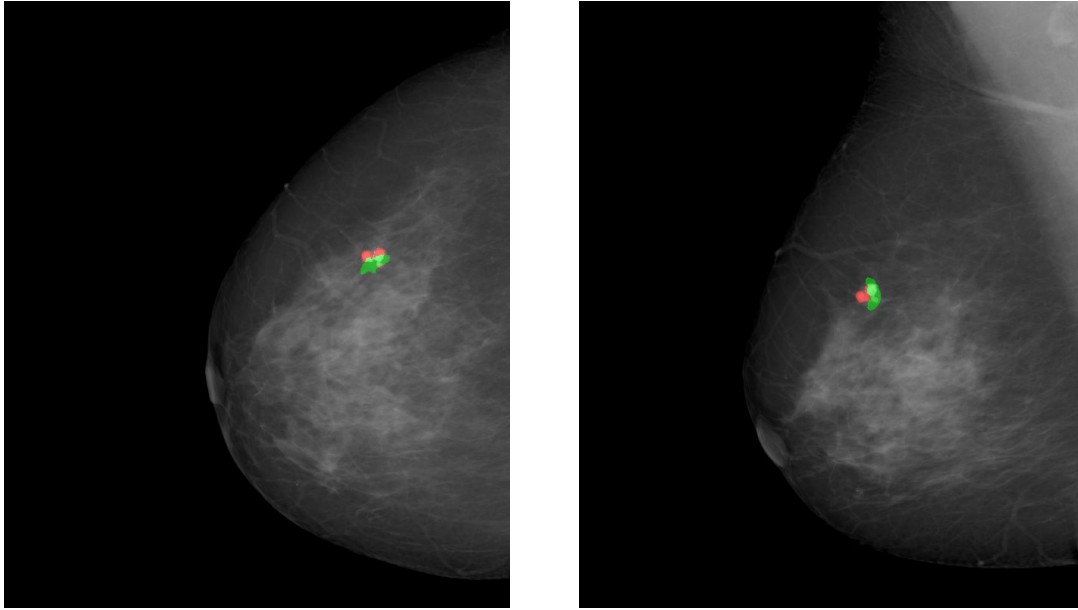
CC and MLO mammograms of the same patient. The red area corresponds to the suspicious regions in the mammograms, while the green area represents the location of the MRI lesion, once the registration has been performed.
